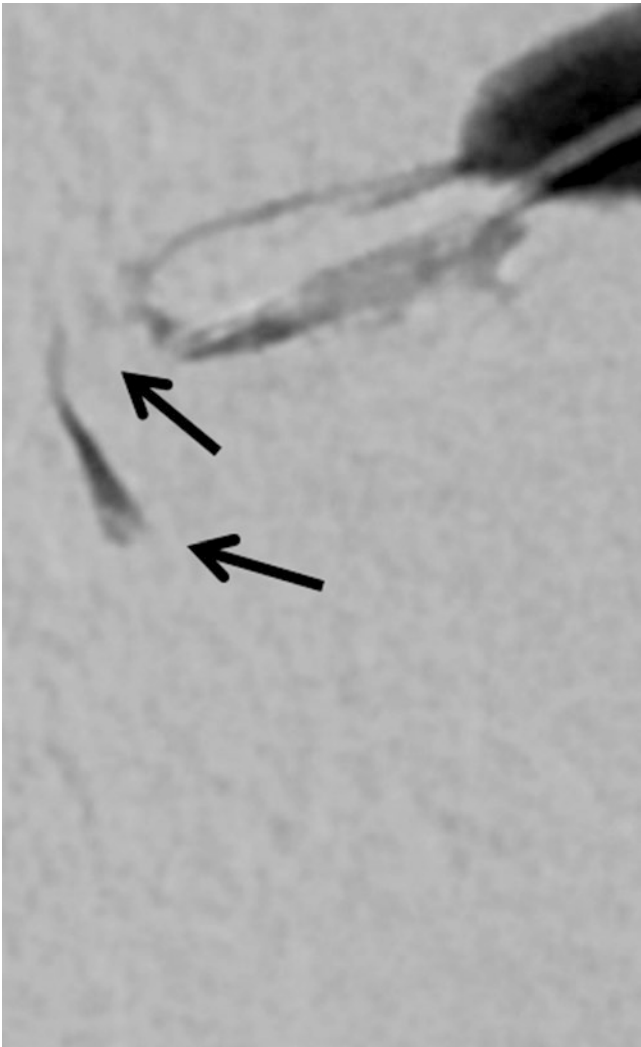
Coexisting pre-sacral stenosis and post-sacral occlusion: radiographic anatomy from digital subtraction dacryocystography (DSD) demonstrates high-grade pre-sacral stenosis of the common canaliculus and post-sacral proximal occlusion
